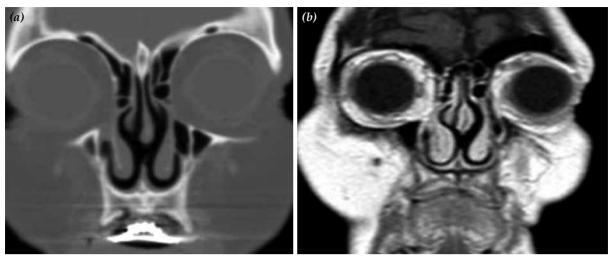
Septal perforation at kaudal septum. (a) Computed tomography. (b) Magnetic resonance imaging.
